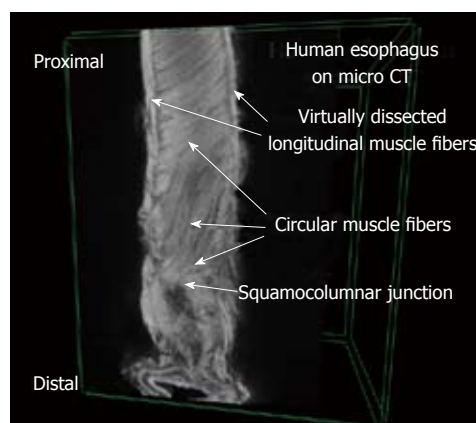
A human esophagus obtained using micro-computed tomography. The longitudinal muscle fibers were virtually dissected to expose the underlying circular muscle fibers. Measurements were made starting from the squamocolumnar junction.
